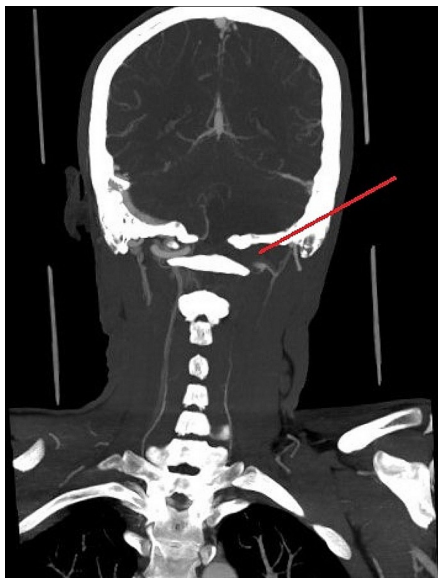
CT angiography showing V4 part occlusion of the left vertebral artery.
